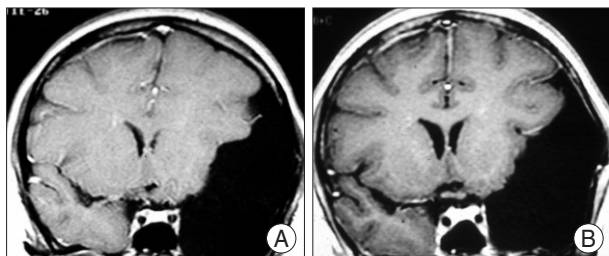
Radiologic findings in case 3. A : Coronal T1-weighted magnetic resonance image revealing an arachnoid cyst in the middle cranial fossa with compression of lateral ventricle and midline shifting. B : Coronal T1-weighted magnetic resonance image obtained 18 months after surgery, demonstrating cyst reduction.
